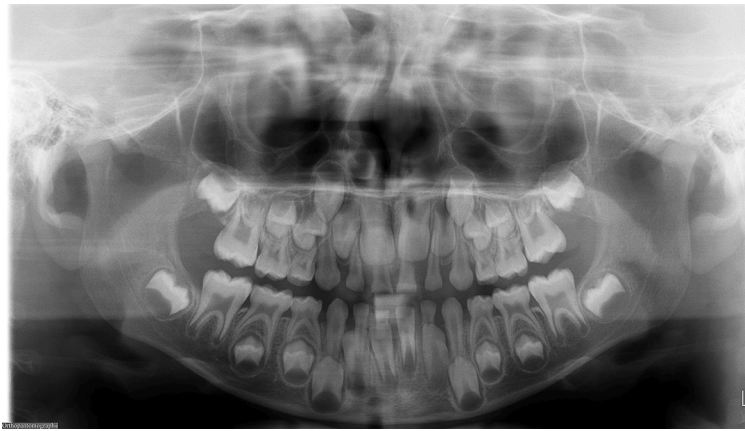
Example of panoramic radiography used by the authors.
